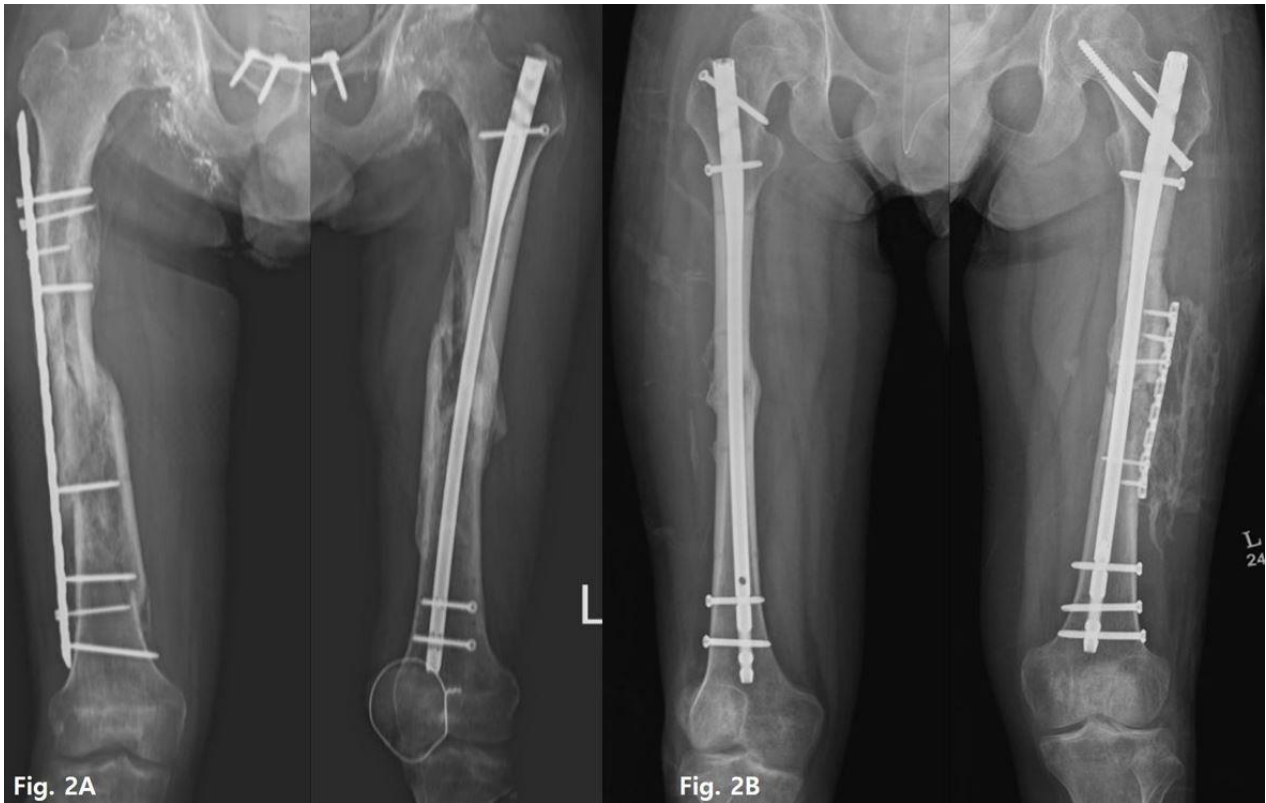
A. Case 1 follow up femur fracture x-ray. B. Case 2 follow up femur fracture x-ray.
